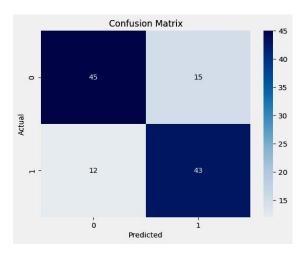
Confusion matrix for the XGBoost classifier. Positive CT findings as 1, Negative as 0.
